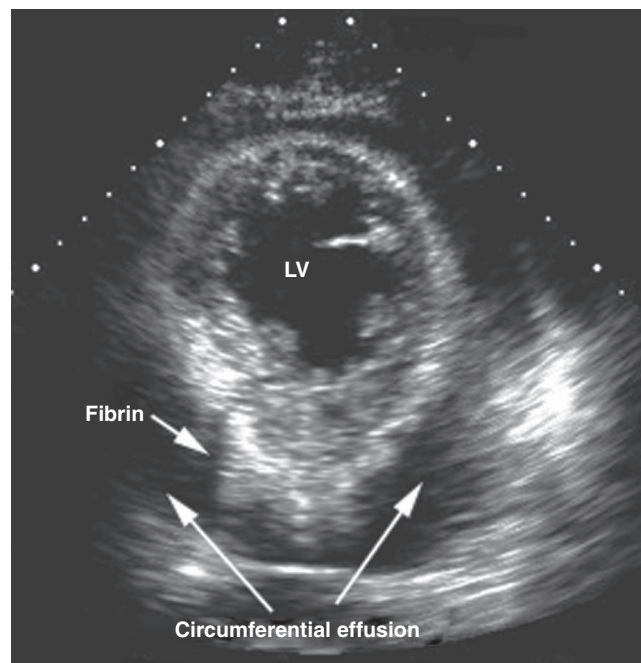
■ Large pericardial effusion. Transthoracic parasternal short-axis view shows a large, predominantly echo-free space around the left ventricle (LV). This space represents fluid in the pericardium. In this case, the large circumferential pericardial effusion was bloody at pericardiocentesis. Particulate matter (e.g., fibrin and clots) can be visualized as denser echoes around the heart and floating in the effusion.
